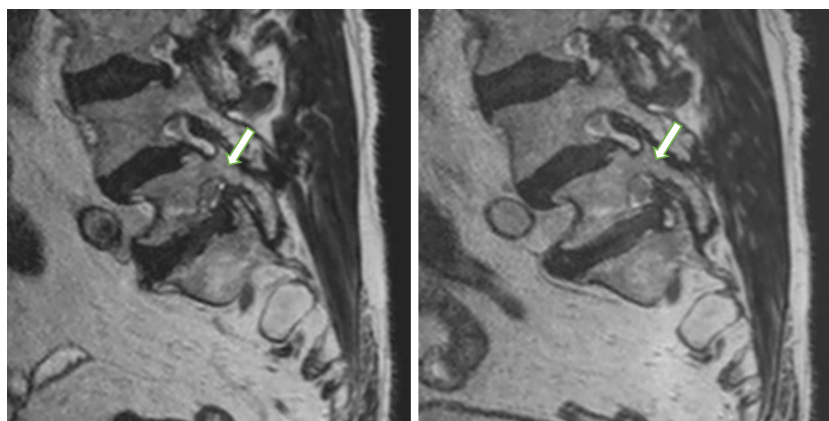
Sagittal magnetic resonance imaging. Morphologic changes in a foraminal zone at L5-S1 (arrow) with nerve root collapse and perineural fat obliteration were seen with and without axial loading.
